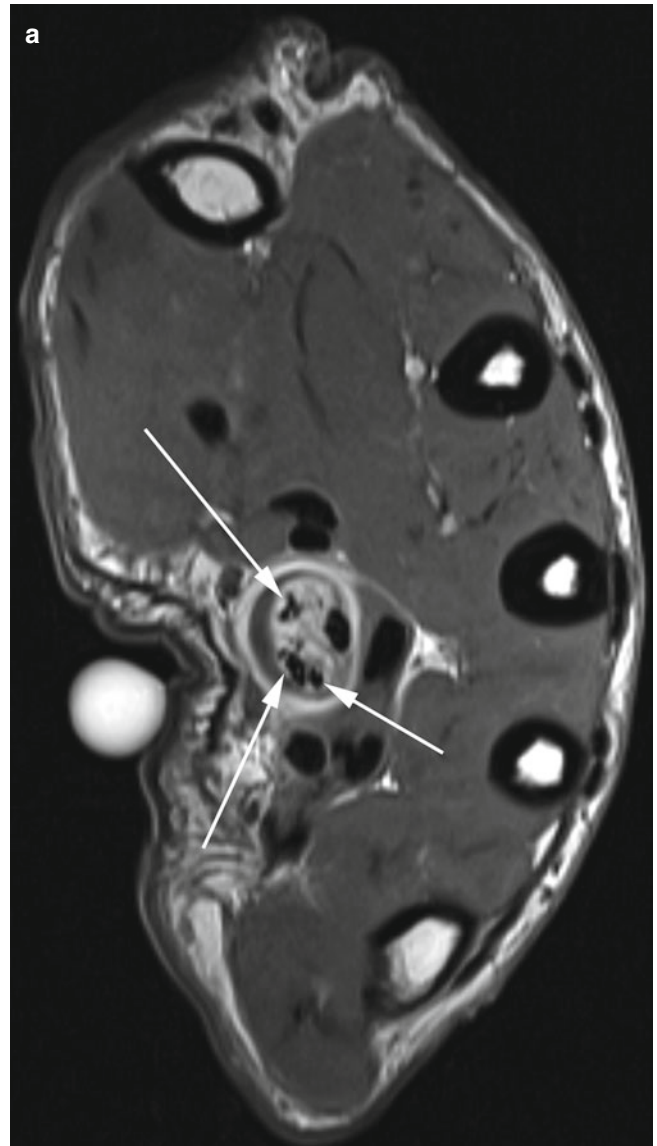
(a) T1-weighted MR image in a patient with high-flow AVM. Multiple small signal voids (*arrows*) are seen inside carpal tunnel and adjacent to the flexor tendons. (b) Grey scale ultrasound image shows hypochoic longitudinal vascular channels (*arrows*) interspersed with flexor tendons (*arrowheads*). (c) Duplex ultrasound demonstrates high arterial systolic flow velocity arterial feeder
